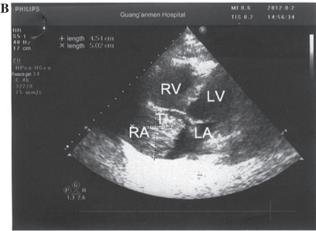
(A) Continuous wave Doppler ultrasonography revealing severe tricuspid regurgitation and severe pulmonary arterial hypertension. (B) Echocardiography scans revealing a 5.0x4.5-cm mass in the RA. RV, right ventrical; LV, left ventricle; RA, right atrium; LA, left atrium; T, tumor.
